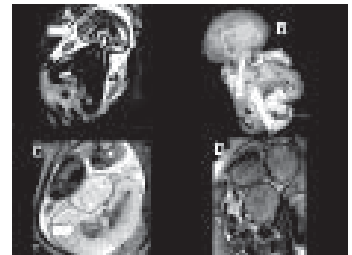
A-D, Fetal MRI in multifetal pregnancy. A, B. Craniothoracoabdominopagus is a rare complex type of conjoining with fusion of the head, neck, thorax and abdomen. Coronal MRI shows fusion of the calvarium, soft tissues of the neck, thorax and abdomen. The brain parenchyma and spines are unfused. Surface rendering 3D reconstruction allow visualization of the fetus as a whole. C. Triplet pregnancy seen on oblique sagittal section demonstrating the three heads of a thirty-four week triplet gestation, simultaneously. D.
